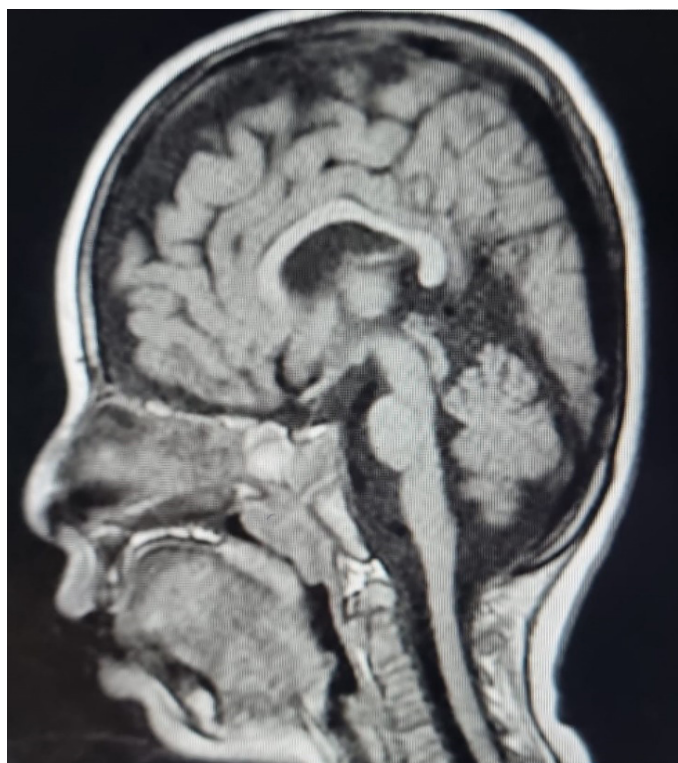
MRI image showed that the arachnoid space was enlarged in the bilateral frontotemporal parietal region.
